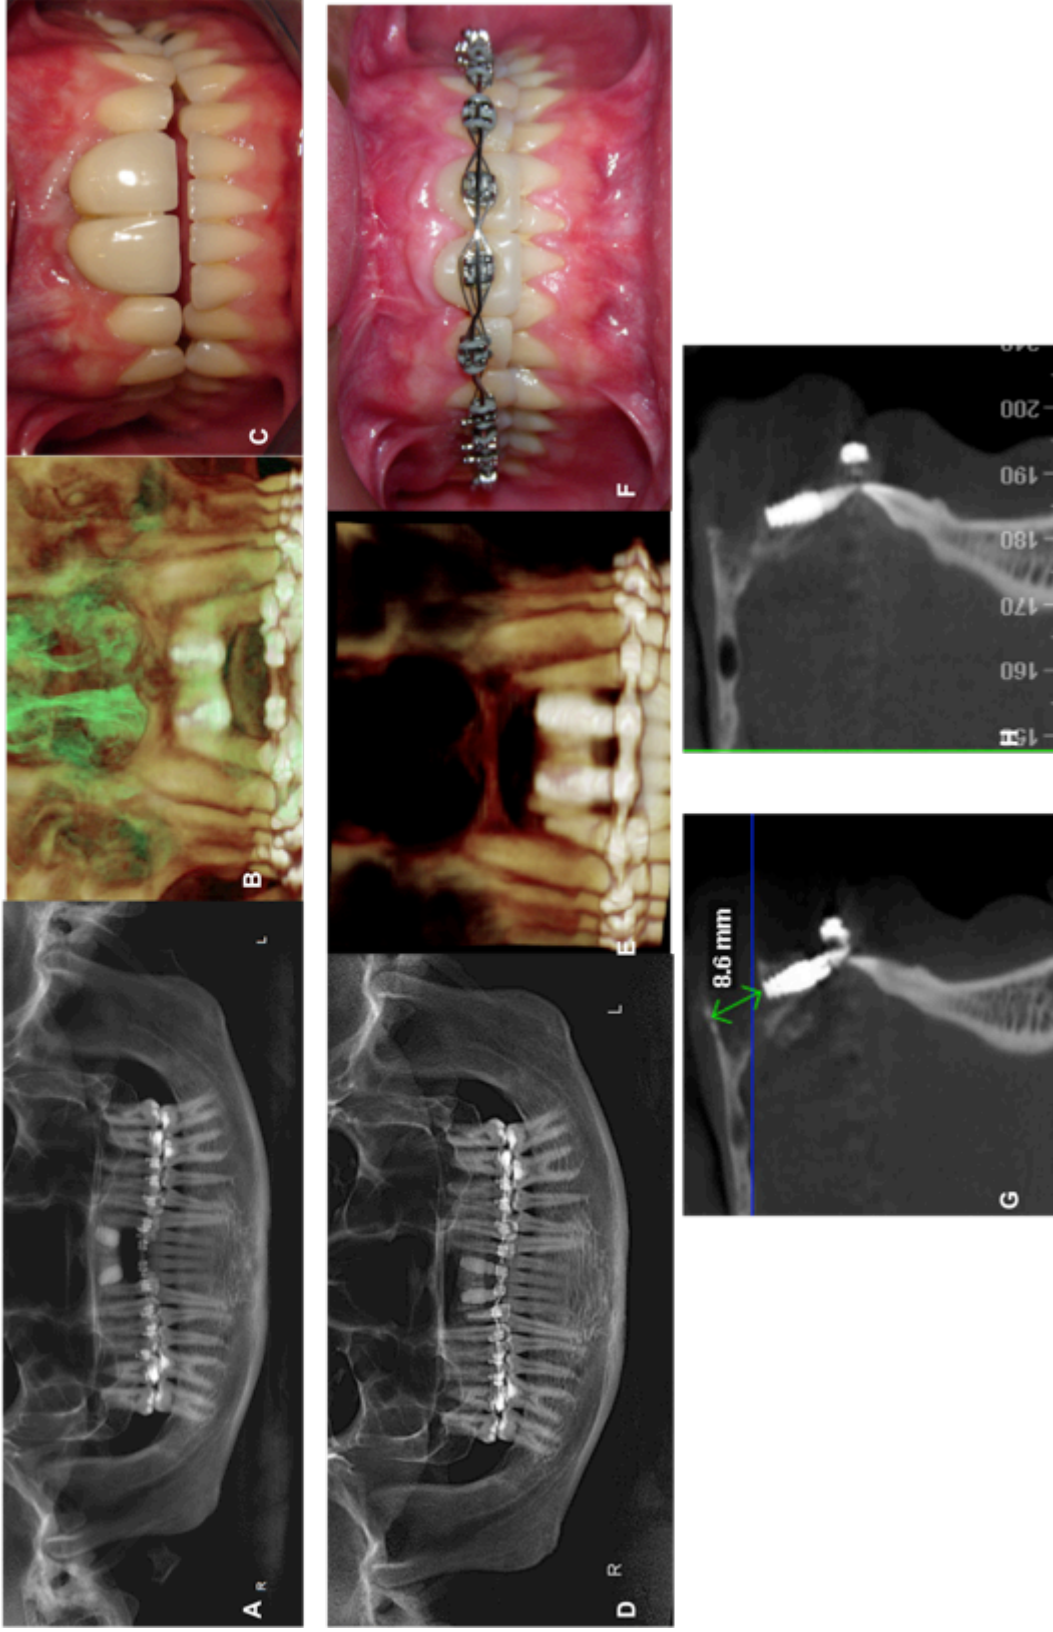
A 27-year-old male patient who underwent bone-block osteodistraction of the maxillary central incisors. A: The orthopantomogram x-ray after installation of the implants; B: A 3D CBCT reconstruction of the showing vertical alveolar bone atrophy at the site of the maxillary central incisors; C: The clinical frontal intraoral view showing the lack of papilla formation between the central incisors crowns and long crowns; D and E: The orthopantomogram x-ray and 3D CBCT reconstruction of the after implant-bone block osteodistraction. A gap is observed subapical to the implants, and the maxillary right lateral incisor was submitted to endodontic treatment due to loss of pulp vitality; F: The clinical frontal intraoral view 6 months postoperatively. A complete formation of papillae occurred between implants (score 3); G and H: A sagittal CBCT slice of the showing a bone gap of 8.6 mm at the site of the maxillary left central incisor implant and the bone formation in the gap 6-months postoperatively.
